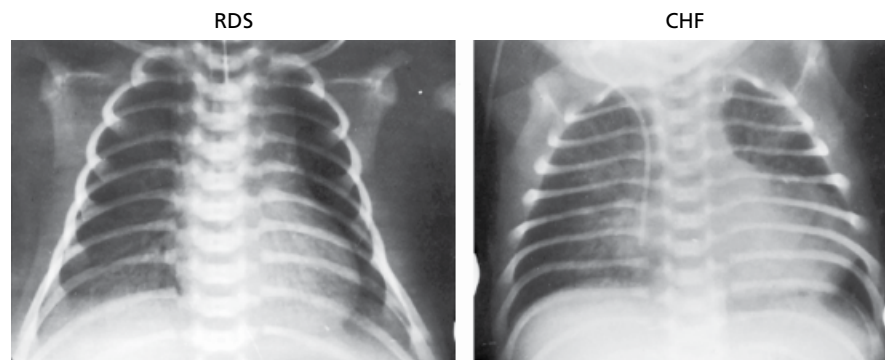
Chest x-rays of a normal preterm infant with respiratory distress syndrome (*left*) and one with a patent ductus arteriosus and congestive heart failure (*right*). Note the enlarged heart, the central fluffiness, and the loss of clear vascular shadows in the latter. Source: Courtesy of Dr Robert C. Brasch.
